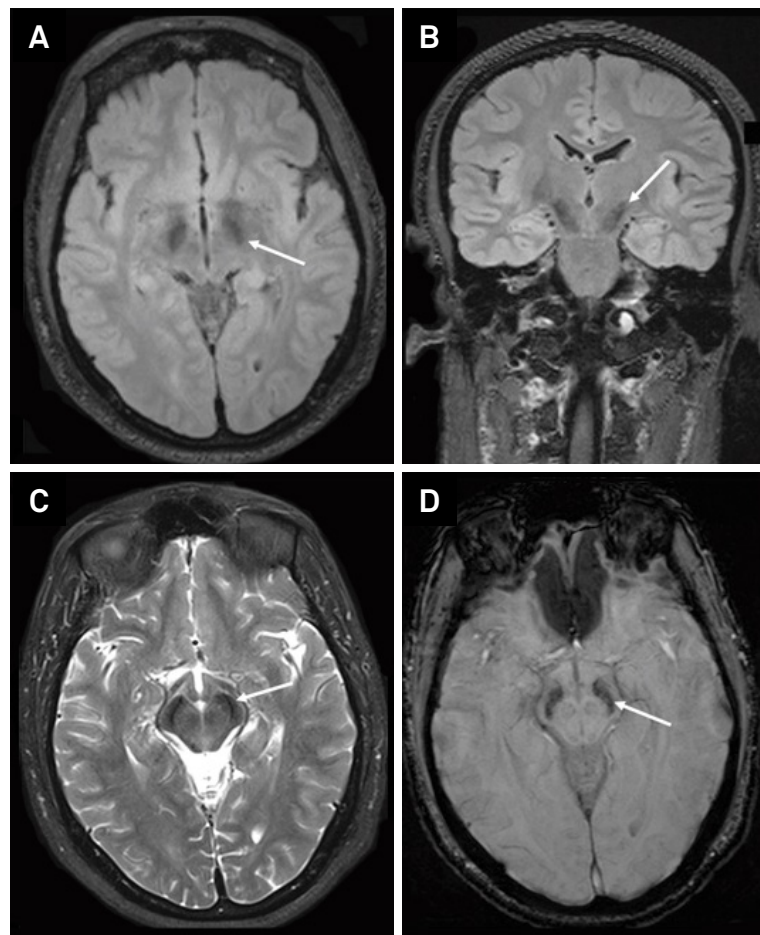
Brain MRI of a patient with beta-propeller protein-associated neurodegeneration (BPAN) or SENDA. There is a marked bilateral hypointense signal in substantia nigra observed in axial and coronal FLAIR (A and B), axial T2 (C) and axial SWI (D) sequences.
